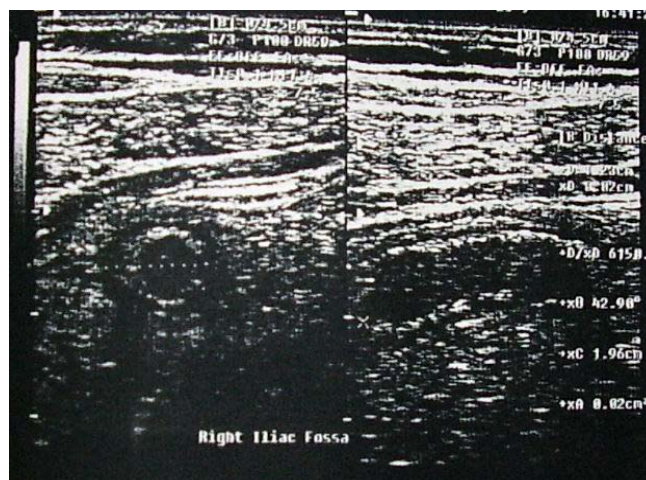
Transverse and longitudinal sonogram of a acute appendicitis shows transverse diameter >6 mm.
